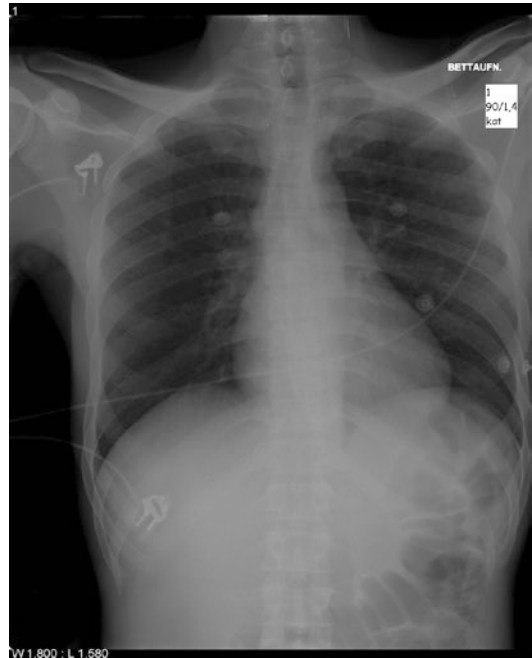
A 52-year-old HIV-positive male with miliary tuberculosis: frontal radiograph showing multiple vague nodular lesions in both the lungs
